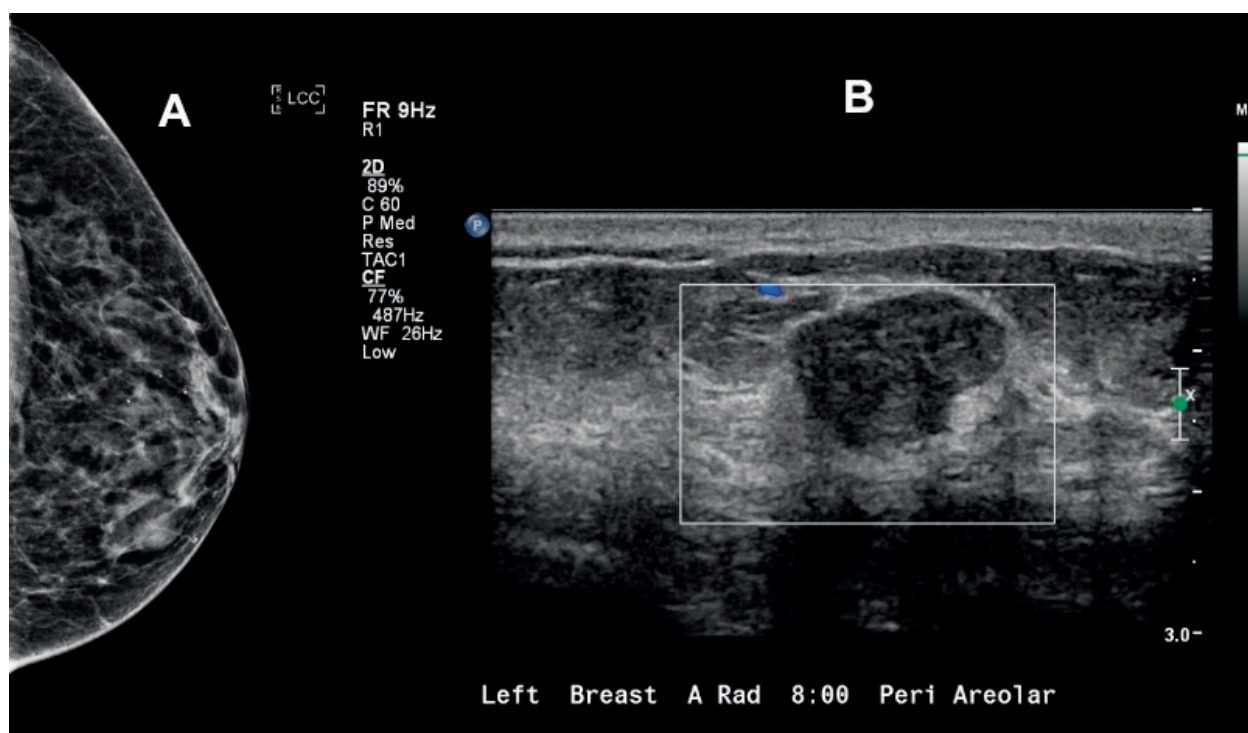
Lesion visibility. (A) CC mammogram of the left breast and (B) transverse ultrasound of the left breast.
